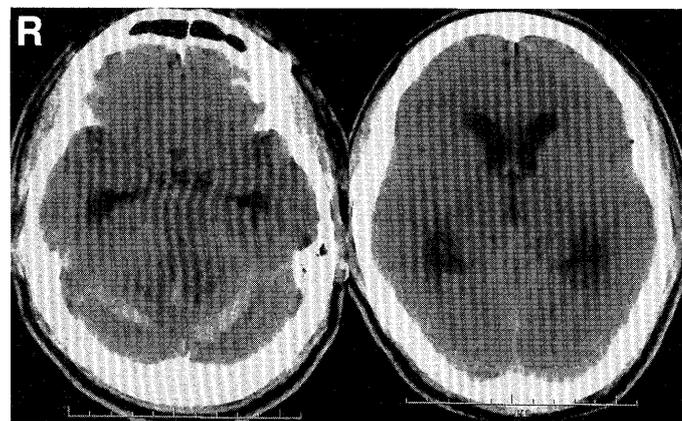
Computed tomography scans of the brain 3 days after the spinal surgery revealing bilateral cerebellar hemorrhages facing the tentorium.
